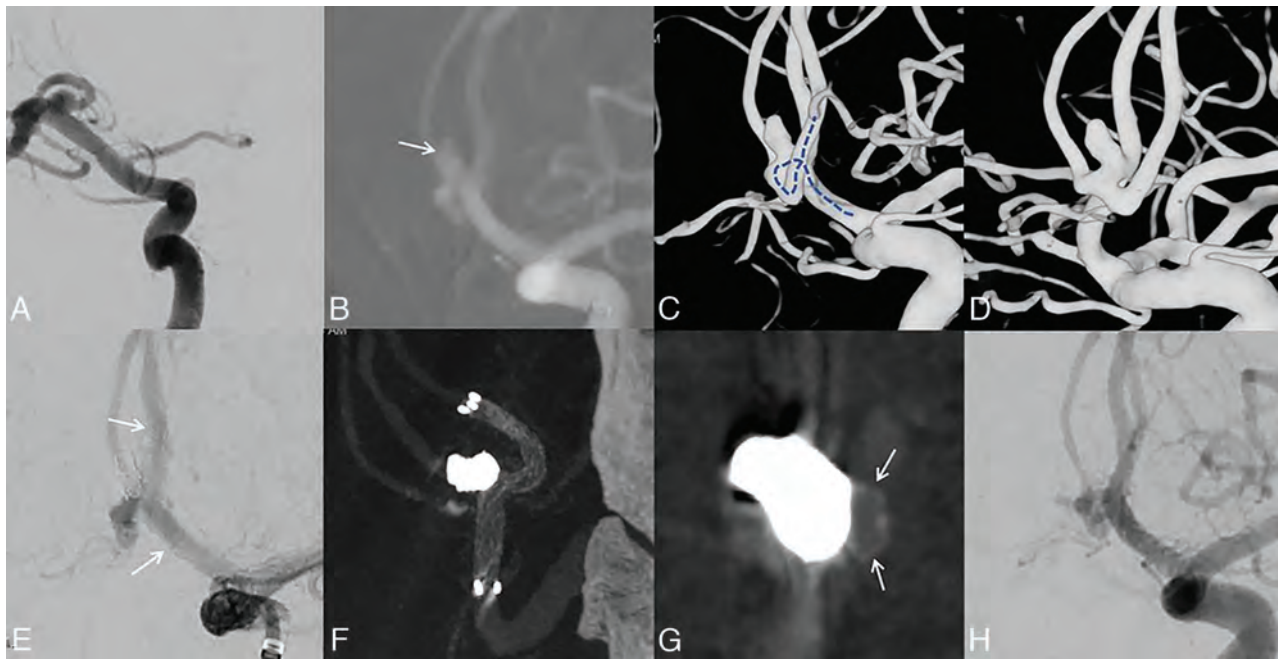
Use of the Neuroform Atlas stent in SAC for the treatment of an unruptured anterior communicating artery aneurysm. A, 2D DSA of the right ICA shows the right A1 artery to be slender and the anterior communicating artery to be open. B, 2D DSA of the left ICA shows an aneurysm of the anterior communicating artery of 2.2×4.5 mm. The anterior communicating artery sends out a median callosal artery and the bilateral A2 arteries together to form a triploid anterior cerebral artery (aneurysm is shown by a white arrow). C and D, 3D DSA shows the position between the 3 A2 arteries and the aneurysms (blue dashed line denotes the stent-placement area, the parent artery diameter is 1.91 mm, and the diameter mismatch ratio is 1.09). E, SAC using a Neuroform Atlas stent (3.0×24 mm) was performed, and the occlusion attenuation of the aneurysm was Raymond-Roy class I (white arrows indicate the ends of the stent). F and G, HR-CBCT with diluted contrast media shows complete stent apposition and satisfactory protection of the coils at the aneurysm neck (the stent wire at the aneurysm neck is indicated by white arrows). H, DSA follow-up at 6 months shows the stent patency and well-healed aneurysm (Raymond-Roy class I).
